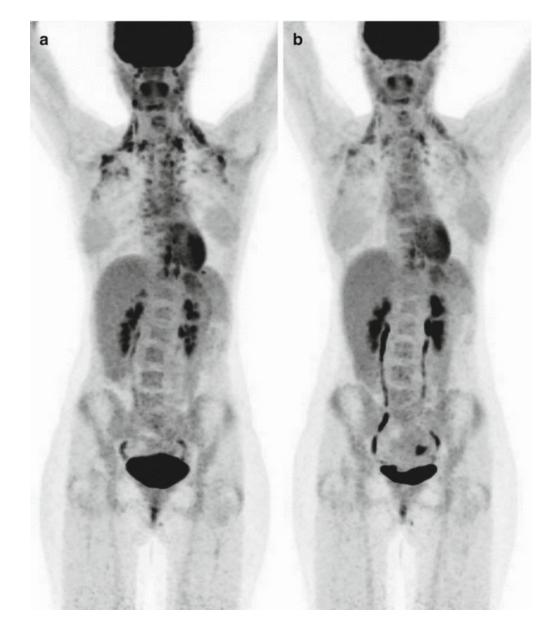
28 year old female patient suffering from paraganglioma undergoing repeated PET/CT due to increased tracer uptake in disseminated brown adipose tissue. PET maximum intensity projection images are displayed. In the initial scan, a markedly increased tracer uptake can be observed in brown adipose tissue in the cervical and the mediastinal area (a). The second scan was performed after propanolol administration. Furthermore, the patient was kept warm during the tracer uptake phase, leading to a markedly reduced tracer accumulation in the brown adipose tissue (b)
